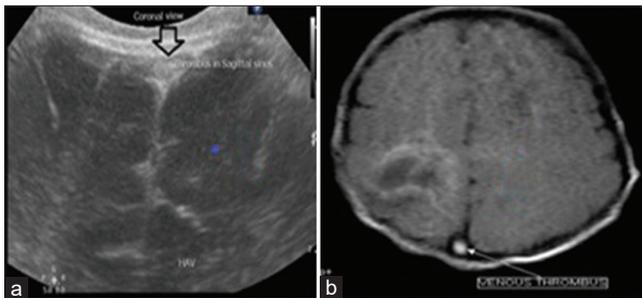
Ultrasound (a) and computed tomography of brain (b) demonstrating venous thrombus in the superior sagittal sinus.
